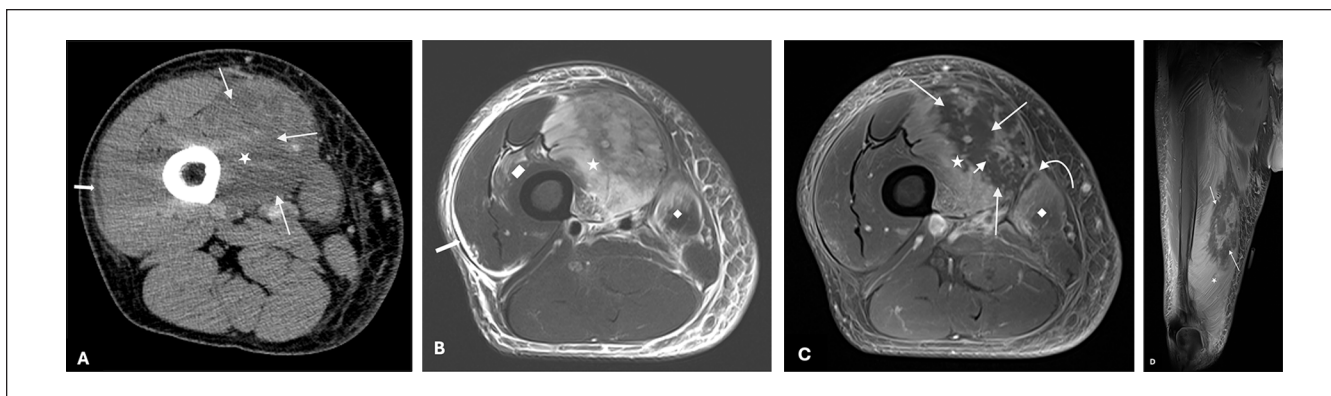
Diabetic myonecrosis in the right thigh. (A) Axial contrast-enhanced CT scan image of mid-thigh demonstrates enlargement of the vastus medialis muscle (*star*) with areas of non-enhancement (*thin long arrows*). There is also a small amount of subfascial fluid collection in the anterior lateral compartment (*thick arrow*) and mild subcutaneous edema which is likely reactive. (B) Axial T2-weighted fat-suppressed MR image demonstrates heterogeneously increased signal/edema in the vastus medialis muscle (*star*) and to a lesser degree sartorius muscle (*diamond*), vastus intermedius (*rectangle*) and other thigh muscles (not shown) which may represent muscle ischemia. Diffuse subcutaneous and intermuscular edema with anterior lateral subfascial thin fluid collection noted (*thick arrow*). (C) Mid-thigh axial and (D) anterior thigh coronal T1-weighted fat-suppressed post-contrast MR images demonstrate diffuse swelling and enhancement in vastus medialis (*star*) and sartorius (*diamond*) with areas of non-enhancement in vastus medialis (*thin long arrows*) and sartorius (*curved arrow*) muscles containing some stipple enhancements (*short arrow*) consistent with myonecrosis. No sizable peripherally enhancing organized fluid collection to suggest an abscess.
